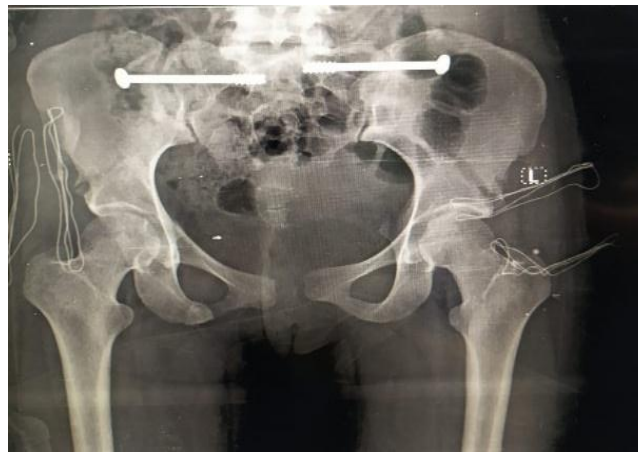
Six months follow up radiographs showing good reduction of the posterior pelvic injury
